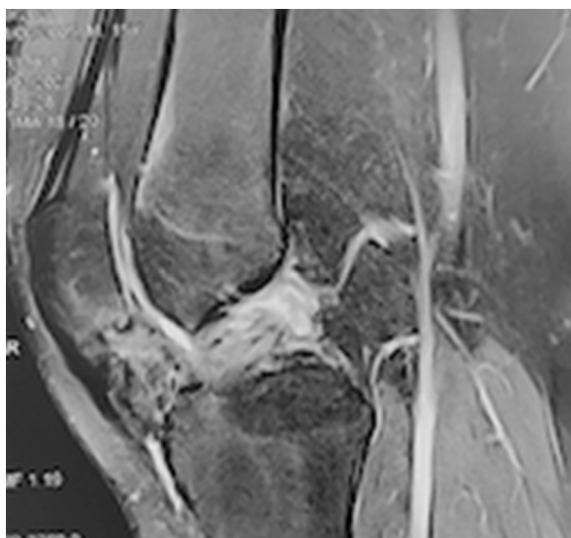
The MRI showed an absence of signs of hemangiomas recurrence and an intra-articular fibrosis was made diagnosis.
